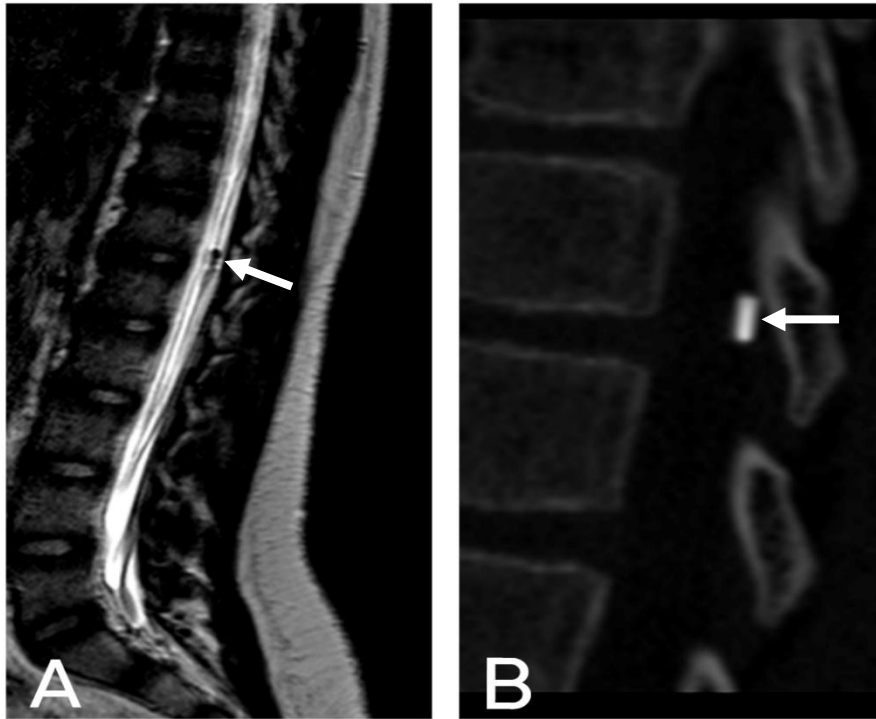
example case of false positive; an apparent nodular lesion visible in the thoracolumbar region in 3D DRIVE (arrow, A) was revealed to be a surgical clip by CT scan (arrow, B).
